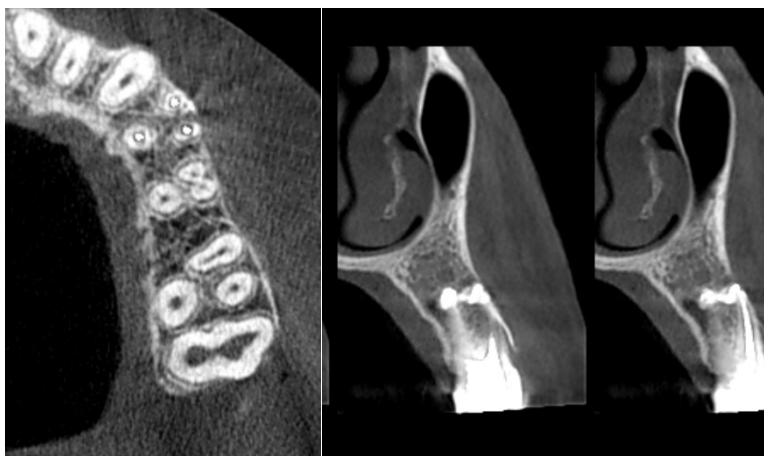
Axial and coronal CBCT images confirming three distinct roots and extrusion of material into periapical tissues
